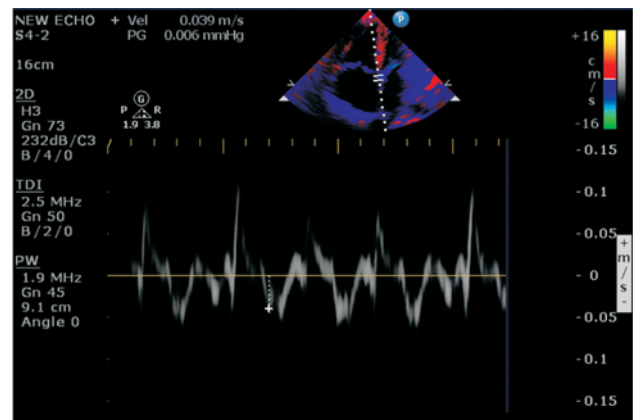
Tissue Doppler imaging at medial mitral annulus showing early systolic velocity $E' = 3.9\text{cm/sec}$.
